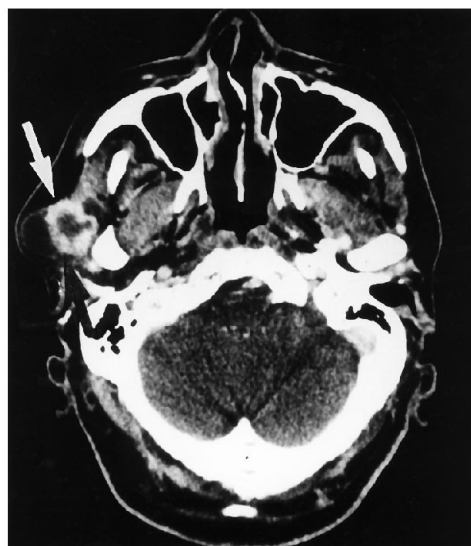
Contrast-enhanced CT demonstrates an enhancing tumor margin (*arrow*) with central low density adhering to the masseter muscle in the superficial lobe of right parotid gland.
